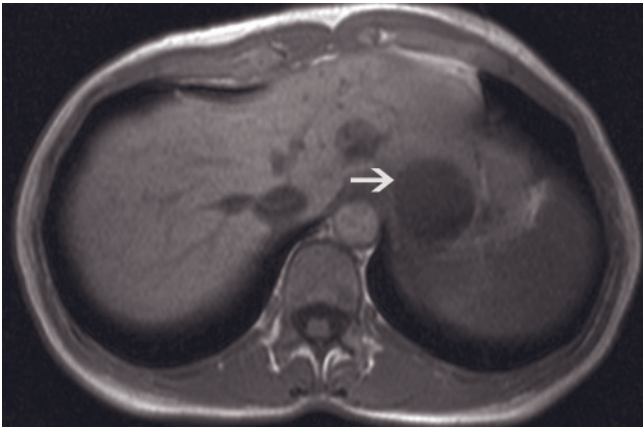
Medium-sized slow-enhancing hemangioma, Type 3 enhancement. Echo train-STIR (*a*), SGE (*b*), and immediate (*c*, *d*) and 90-s fat-suppressed (*e*) postgadolinium SGE images. A lobular lesion is present that demonstrates moderately high signal intensity on the T2-weighted image (*a*) and moderately low signal intensity on the T1-weighted image (*b*), small peripheral nodules
